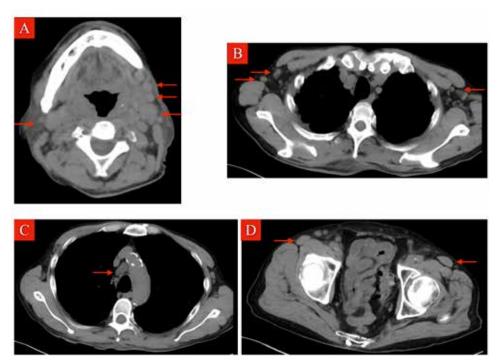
Whole-body CT findings at the first visit (on day 1 of consultation)
